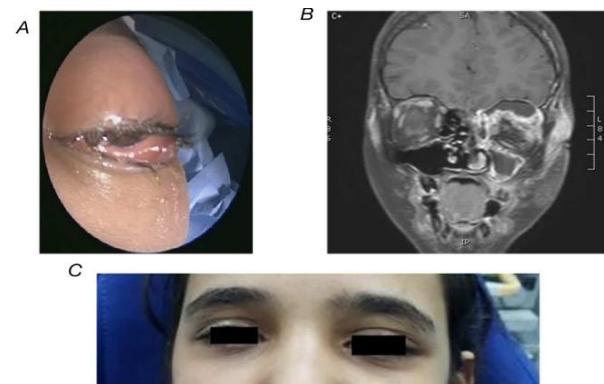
(A) Severely infected left eye with restricted movement, (B) CT sinuses and orbit with inflamed frontoethmoid sinuses and orbital abscess, and (C) the child is fully recovered six weeks post-treatment.
